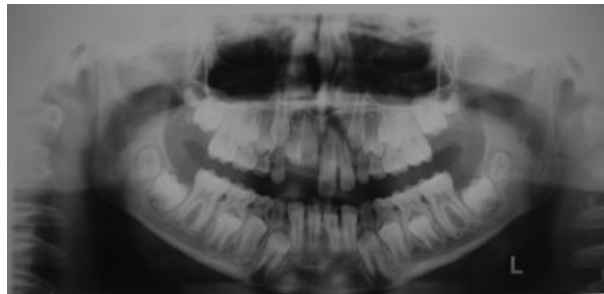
Panoramic radiograph showing impacted permanent maxillary right lateral and central incisors.
